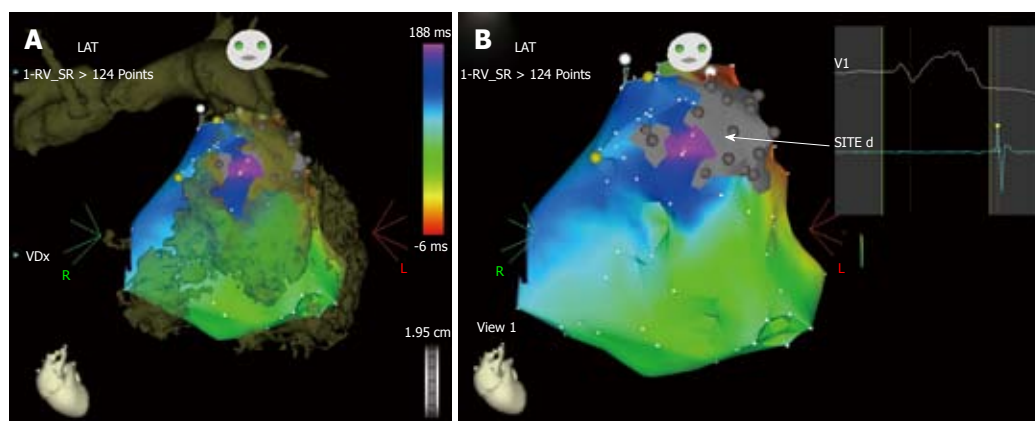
Imaging integration for ablation of ventricular tachycardia (A, B). Example of integration of a computed tomography image in the three-dimensional electroanatomic system. This patient had ventricular tachycardia years after multiple surgical corrections for tetralogy of fallot with pulmonary artery stenosis. He was referred for multiple recurrences of drug-refractory ventricular tachycardia with two morphologies, both with left bundle branch morphology and inferior axis deviation. However, no arrhythmia was inducible during the electrophysiology testing. Therefore, the ablation strategy was based on substrate mapping in sinus rhythm with imaging integration (Figure 4). A: The three-dimensional rendering of the computed tomography (image in brown) of the right ventricle and pulmonary artery is superimposed on the electroanatomic mapping of the right ventricle in sinus rhythm. The merging of the two images helps reconstruct the geometry of the heart chamber and, particularly in this case, clarifies the anatomy of the right ventricular outflow tract, identifying precisely the pulmonary valve annulus, an essential landmark for ablation. The right ventricle appears hypertrophic and markedly dilated; B: The activation map in sinus rhythm is shown in the antero-posterior projection without the integrated image. There is a markedly delayed activation in the anterior wall of the outflow tract (in purple), in a channel between two electrically silent areas (in gray) related to previous surgery (ventriculotomy and positioning of a prosthetic patch). This channel (arrow) shows late bipolar recordings, after the end of the surface QRS (panel on right hand side) and could possibly be related to one morphology of ventricular tachycardia. During sinus rhythm, the earliest activated site (in red) of the right ventricular endocardium is the ventricular septum, consistent with a breakthrough of activation from the left bundle branch in the presence of a complete right bundle branch block.
